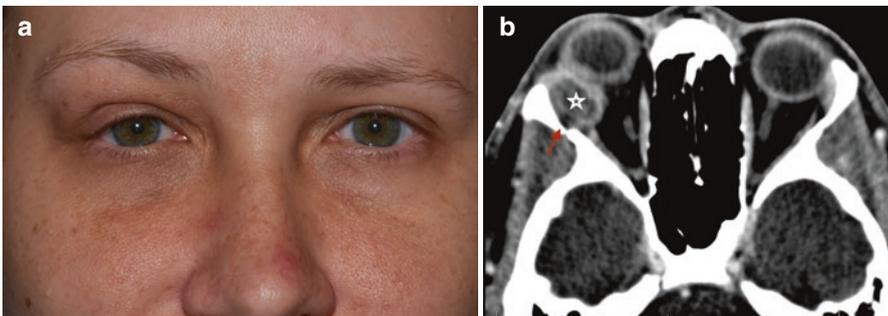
(a) External images of the face show subtle enlargement of the brow fat above the eyelid. The right upper eyelid shows mild ptosis. (b) Axial CT of the orbit shows a cystic mass in the area of the lacrimal gland, lateral and posterior to the right globe (*star*). There is erosion of the lateral orbital wall (*red arrow*)
